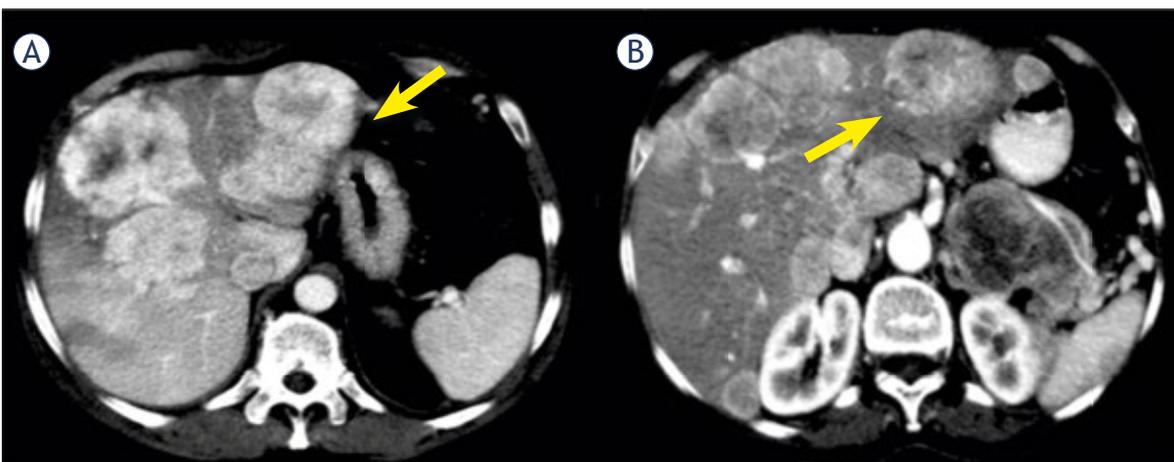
A 52 yrs old female with pancreatic NET. Liver metastases show hypervascular appearance (arrow) during arterial phase of contrast study on CT (A, B).
